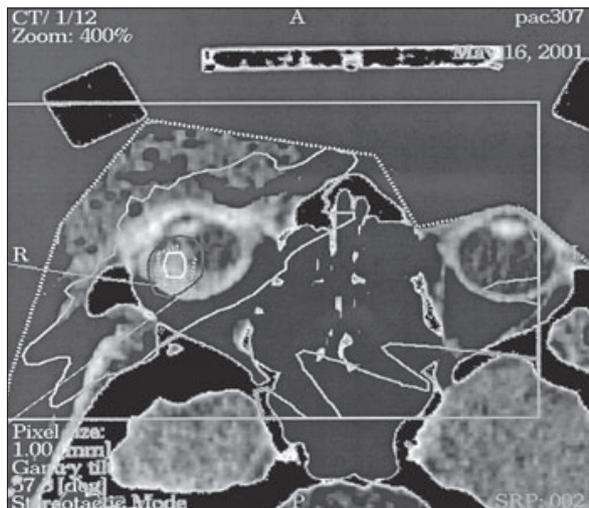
Pre-treatment 3-D planning by computer (superposition of CT and MRI in the basis for planning a dose rate for irradiation by stereotactic radiosurgery)
